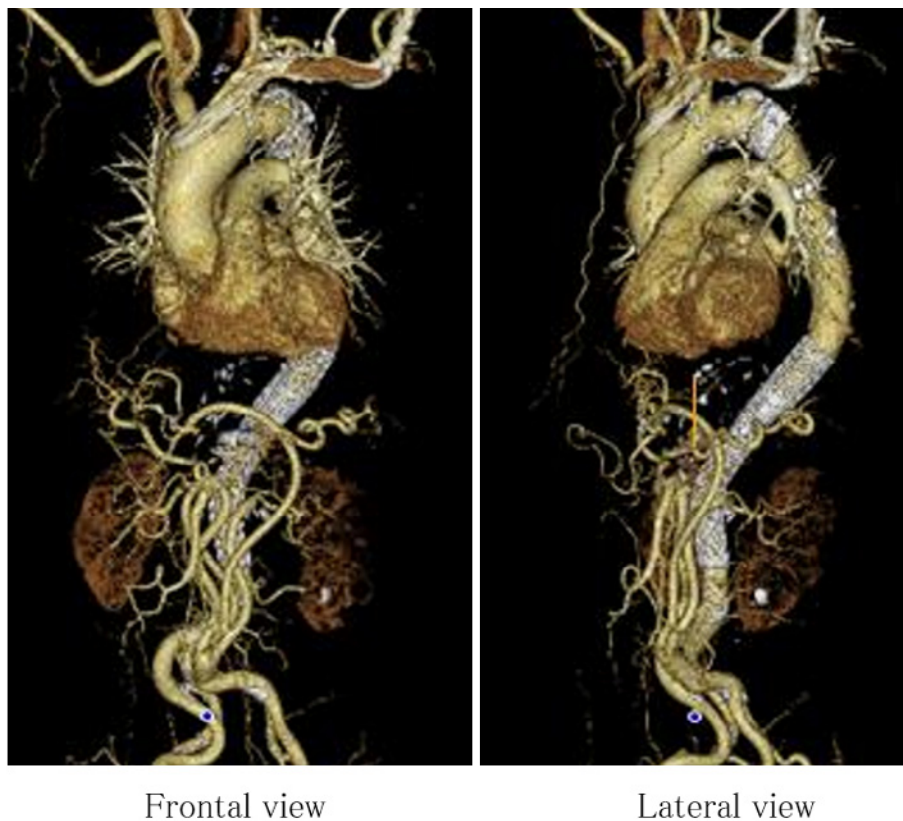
Postoperative 3-dimensional CT scans
